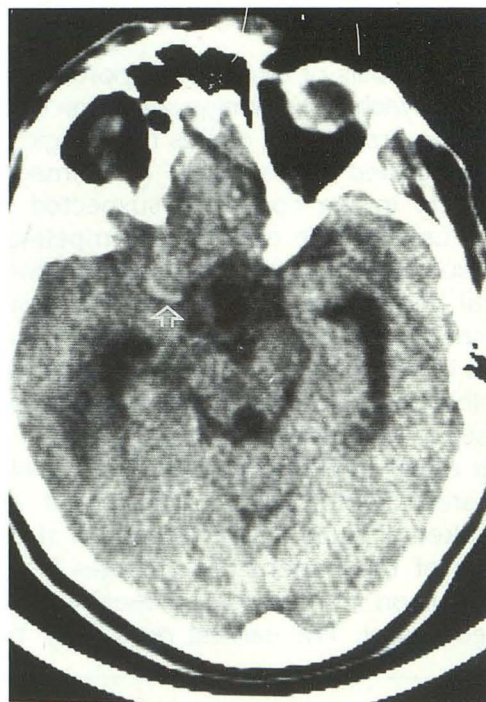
Patient 5. Noncontrast CT scan through the region of the circle of Willis. The MCA on the right is hyperdense (arrow).
